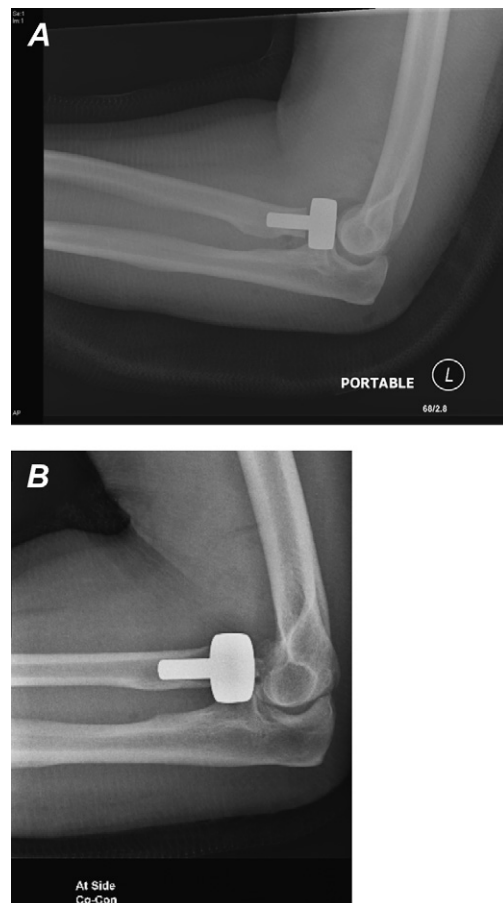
A. Radiographs demonstrating drop sign after terrible triad injury. B. Radiograph taken while patient is performing isometric contraction. Note the decreased gapping of the ulnohumeral joint space.
